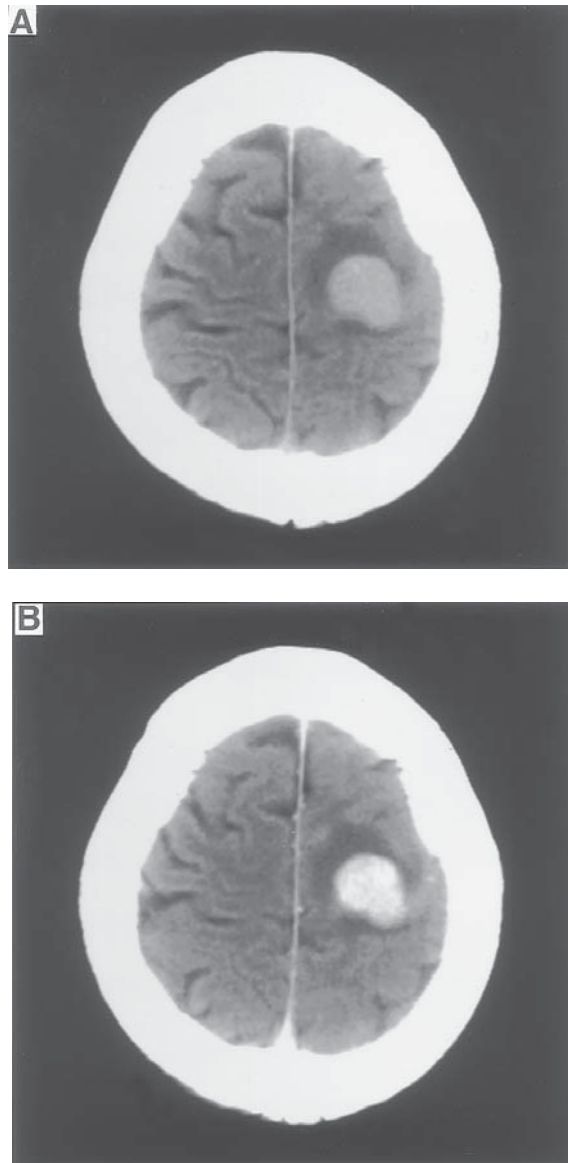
CT of the brain with (A) and without (B) contrast of a single lesion in the frontoparietal region of a 71-yr-old woman with RCC.
